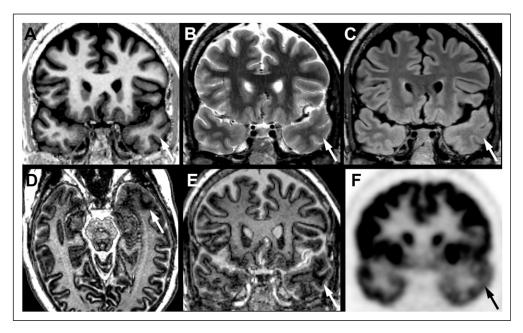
In Patient 2, coronal (a) SPACE inversion recovery, (b) T2-weighted, and (c) FLAIR MRI show no definite asymmetry of the gray-white boundary in the left temporal pole (arrow) and was interpreted as normal. (c) Axial and (d) coronal 3D-EDGE clearly reveal abnormal white matter hypointensity (arrow) in the subcortical white matter of the left temporal pole. (e) Coronal FDG-PET also shows hypometabolism of the left temporal pole (arrow).
